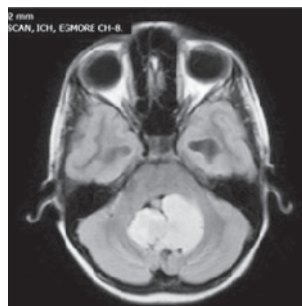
CT brain - Hyperintense midline
